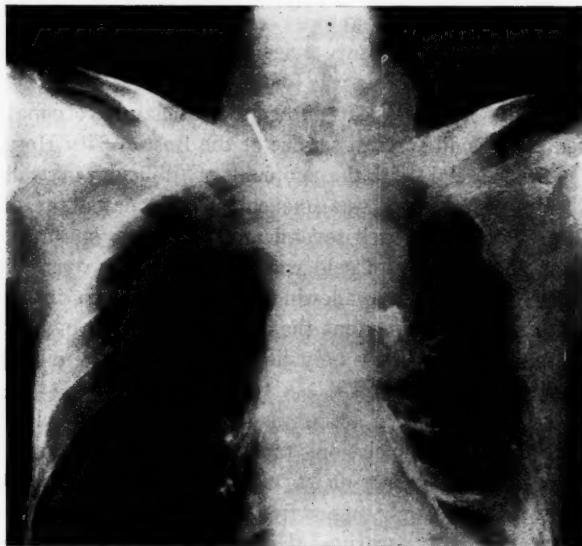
Roentgenogram in anteroposterior position showing barium filled right and left bronchi.
